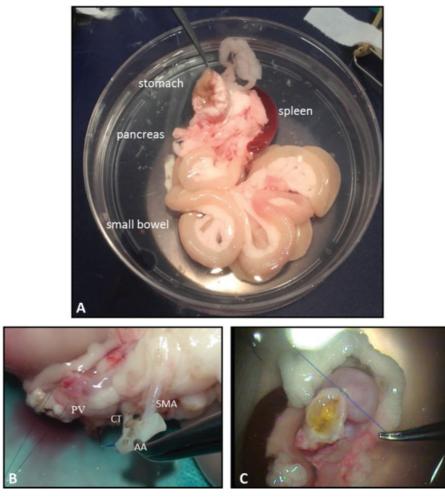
General and detailed aspects of the graft during the back table procedure. (A) Modified multivisceral graft in cold lactate ringer solution. (B) Detail of graft pedicles. (C) Upper gastric section and suture. AA: abdominal aorta conduit including superior mesenteric artery (SMA) and CT, celiac trunk; PV, portal vein.
